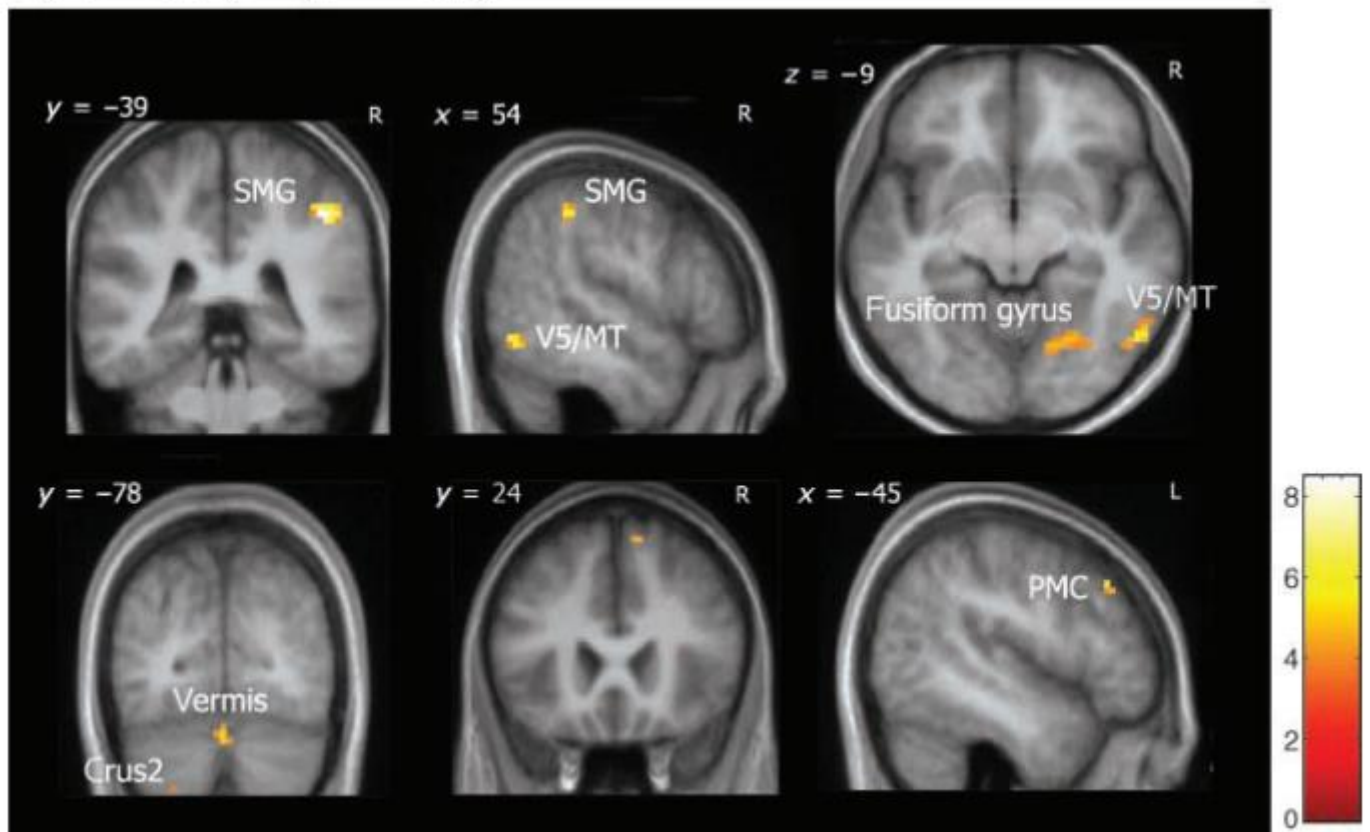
Neural substrates of time perception. *Loci activated by the statistical contrast (A-CA)- (P-CP) overlaid on the average T1-weighted structural image from the 14 subjects in the stereotactic space of Talairach and Tournoux (1988). This contrast shows brain areas where the reproduction task (vs. its control) evoked significantly more activity than the estimation task (vs. its control). Activations were found in the right supramarginal gyrus (SMG), right V5/MT, left fusiform gyrus, cerebellar vermis (all significant $p < .05$, corrected at cluster level), left middle frontal gyrus, right pre-SMA, left premotor cortex, left SMG, bilateral cerebellum (left crus2 and right VIII lobule, all significant $p < .001$, uncorrected, (Bueti et al., 2008)).*
